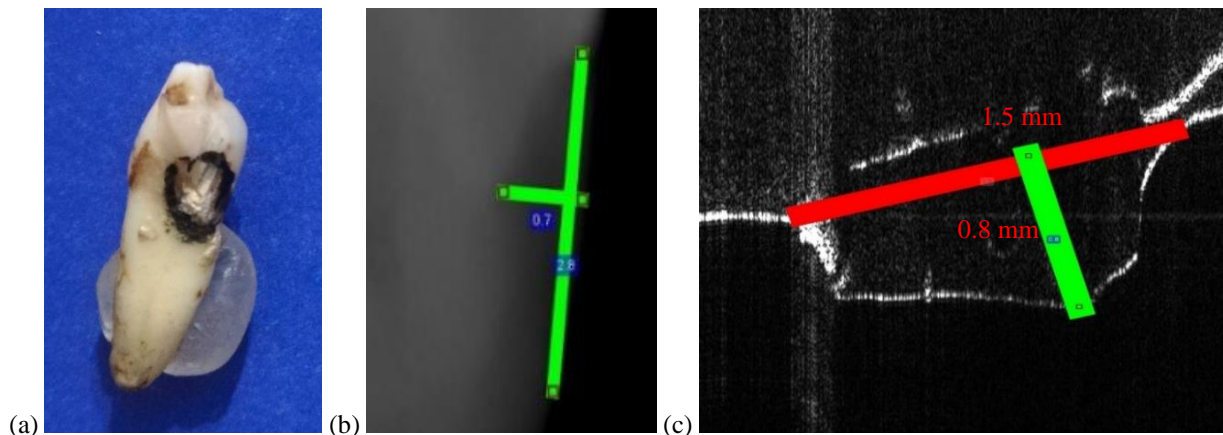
(a) Tooth number 5, marked for OCT investigations; (b) a section from the intraoral radiography with a focus on the measured cavity; (c) a section from an OCT image where the measurements of the cavity were done.
